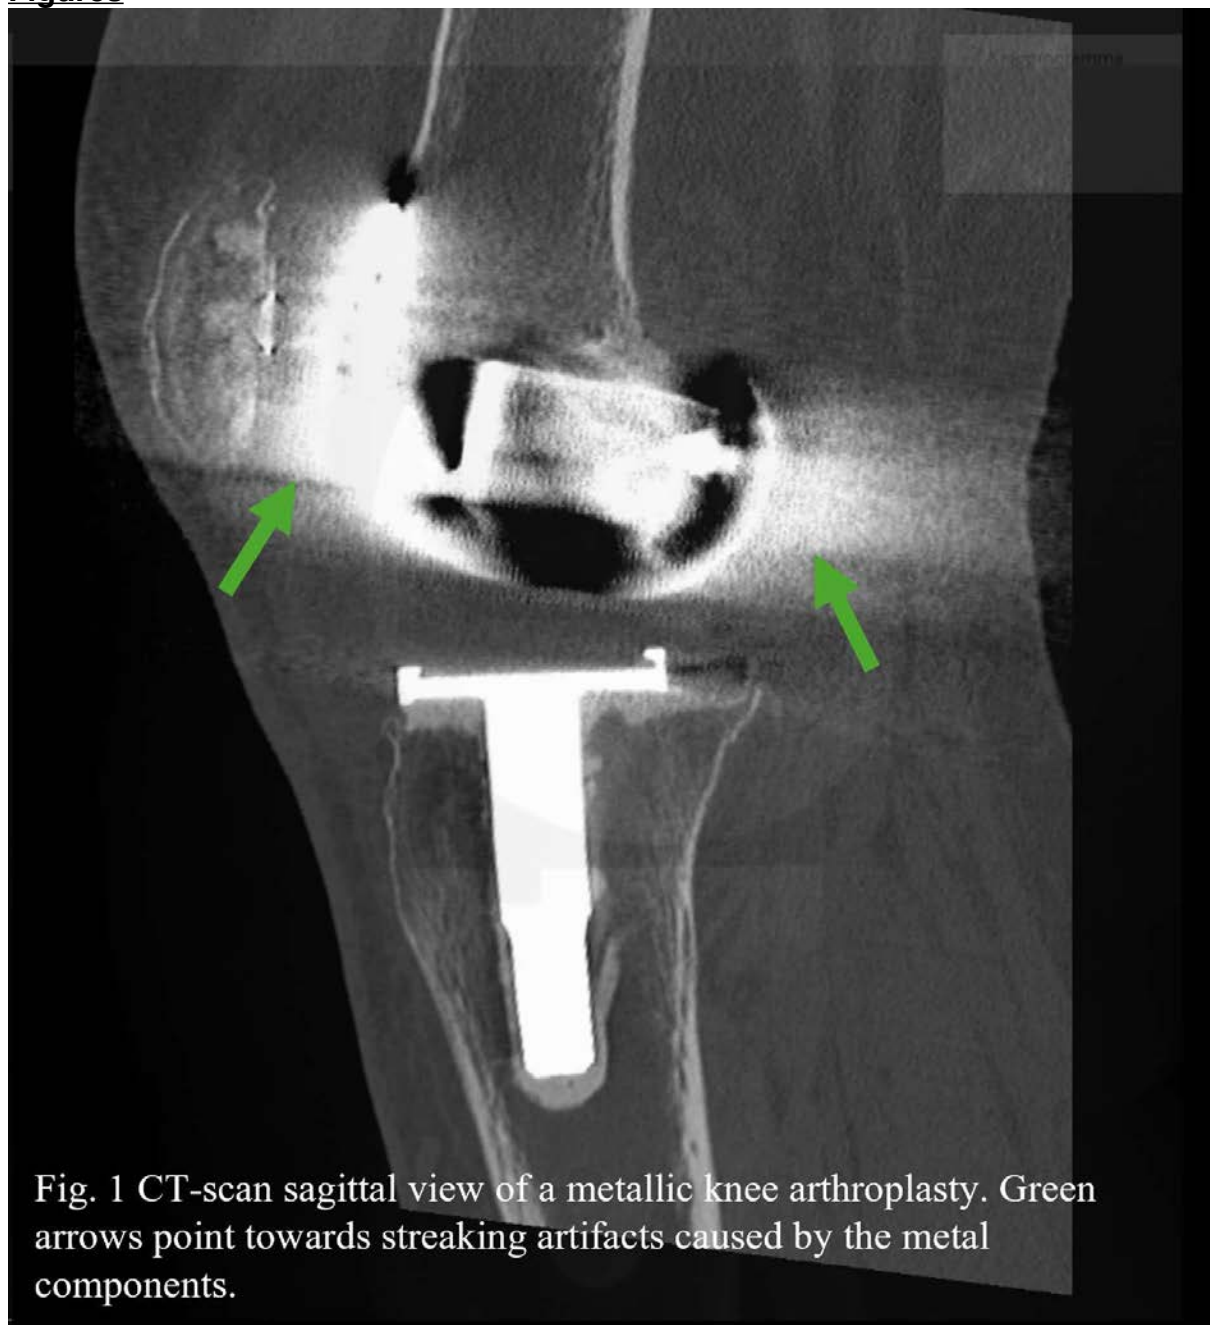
CT-scan sagittal view of a metallic knee arthroplasty. Green arrows point towards streaking artifacts caused by the metal components.
